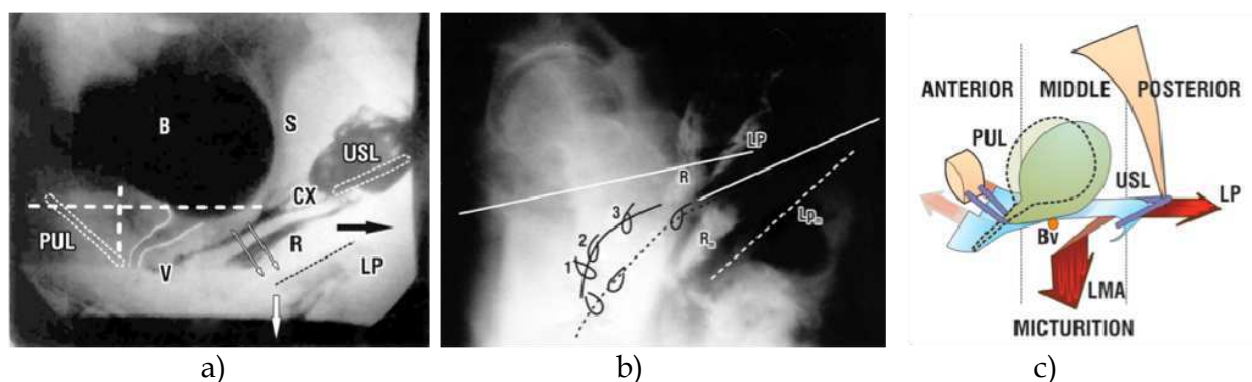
Normal micturition. a) Lateral xray, same patient as fig. 3. During micturition, the bladder and vagina move backwards and downward, opening out the posterior urethral wall. b) Superimposed lateral xray.s At rest (unbroken lines) and micturition (broken lines) vascular clips placed at midurethra "1", bladder neck "2" and bladder base "3". c) Muscle actions during micturition . PCM relaxes. This allows the posterior muscle forces LP/LMA (red arrows) to stretch vagina and posterior urethral wall backwards/ downwards to open out the outflow tract. Same labelling as fig. 3. (From P Petros 2010, by permission).
